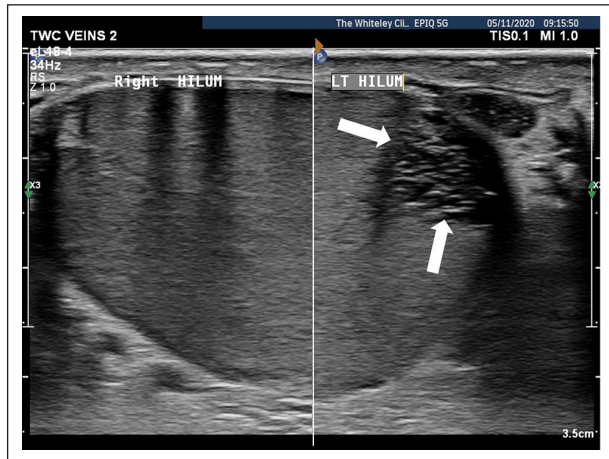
Duplex ultrasound of the hilum of each testicle – right normal and left showing some local oedema (white arrows).
